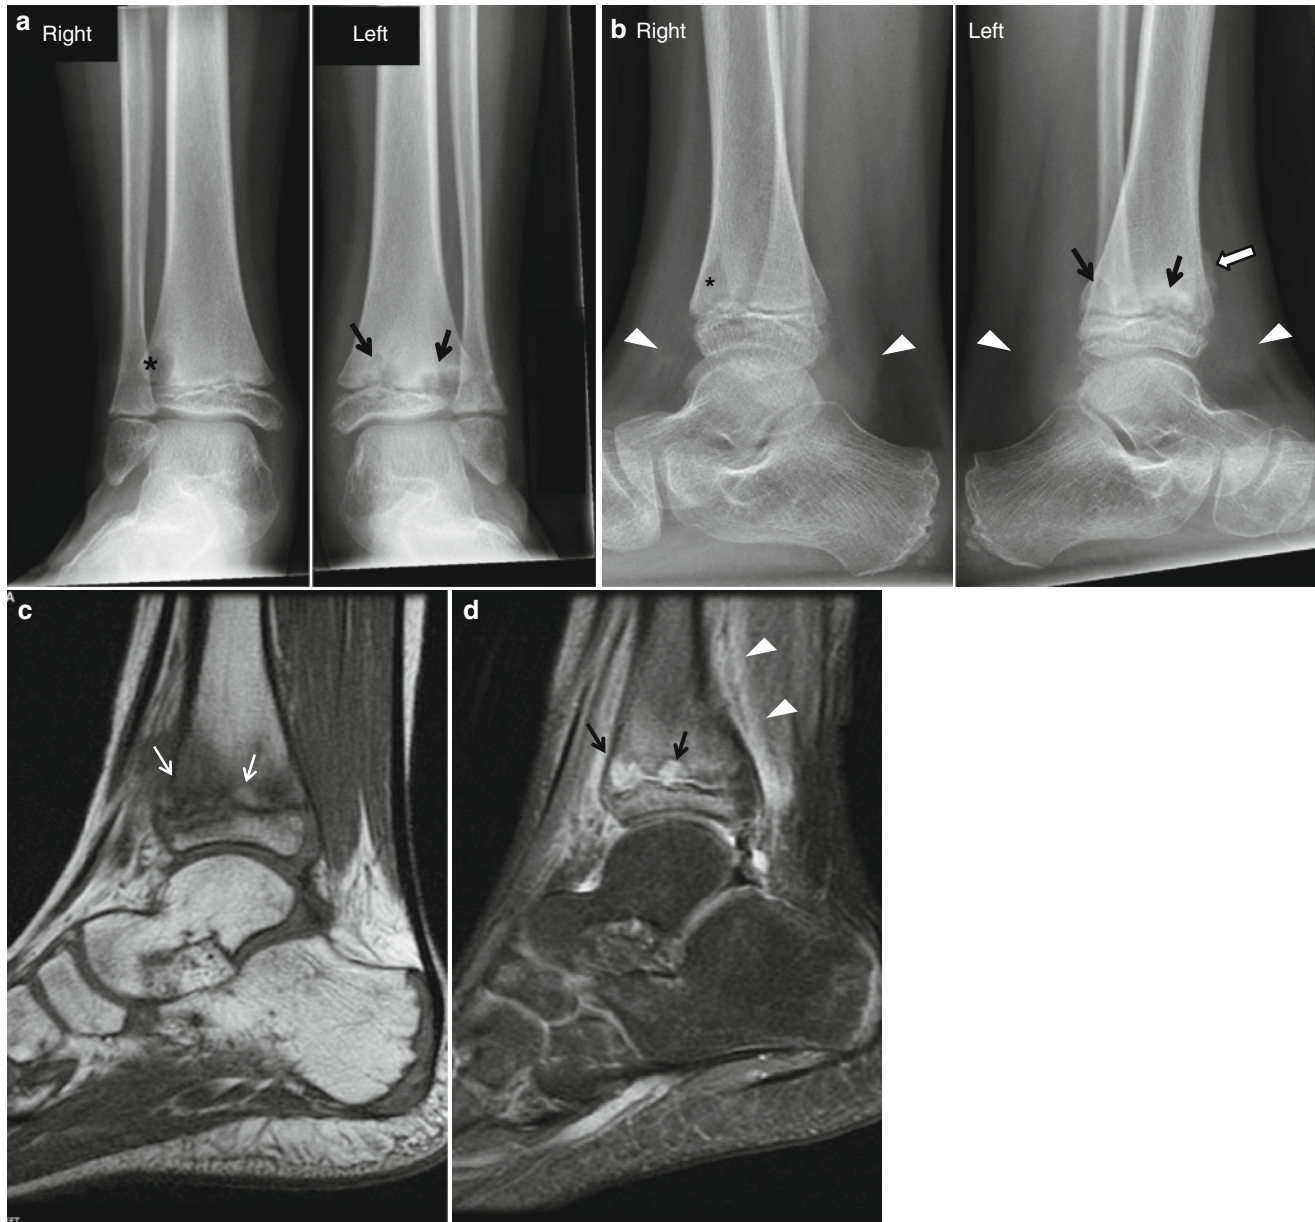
A 14-year-old boy with chronic recurrent multifocal osteomyelitis (CRMO). (a) Frontal radiographs of the ankles demonstrate an osteolytic lesion (*) on the right and metaphyseal sclerosis and lucencies (arrows) on the left. (b) Lateral radiographs demonstrate deep soft tissue swelling (arrowheads), an osteolytic lesion (*), metaphyseal
